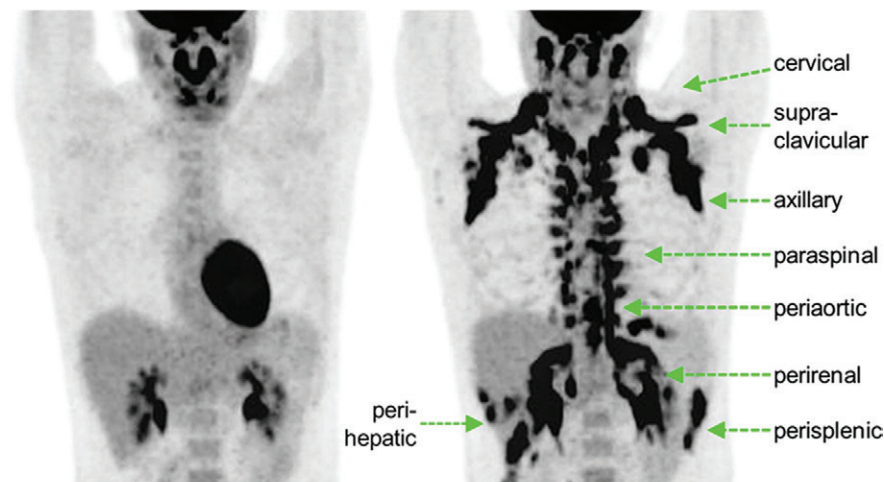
BAT activation in humans with β_3 -adrenergic receptor agonist mirabegron. Twelve subjects underwent ^{18}F -FDG PET after administration of either placebo or 200-mg mirabegron. (a) ^{18}F -FDG PET images in 21-year-old man after administration of placebo (left) and mirabegron (right). There are multiple sites of BAT uptake after mirabegron administration. (b) Graph shows results from all 12 patients. There is a significant increase in detectable BAT after mirabegron administration. Patient identification numbers are listed on graph. (Reprinted, with permission, from reference 9.)
